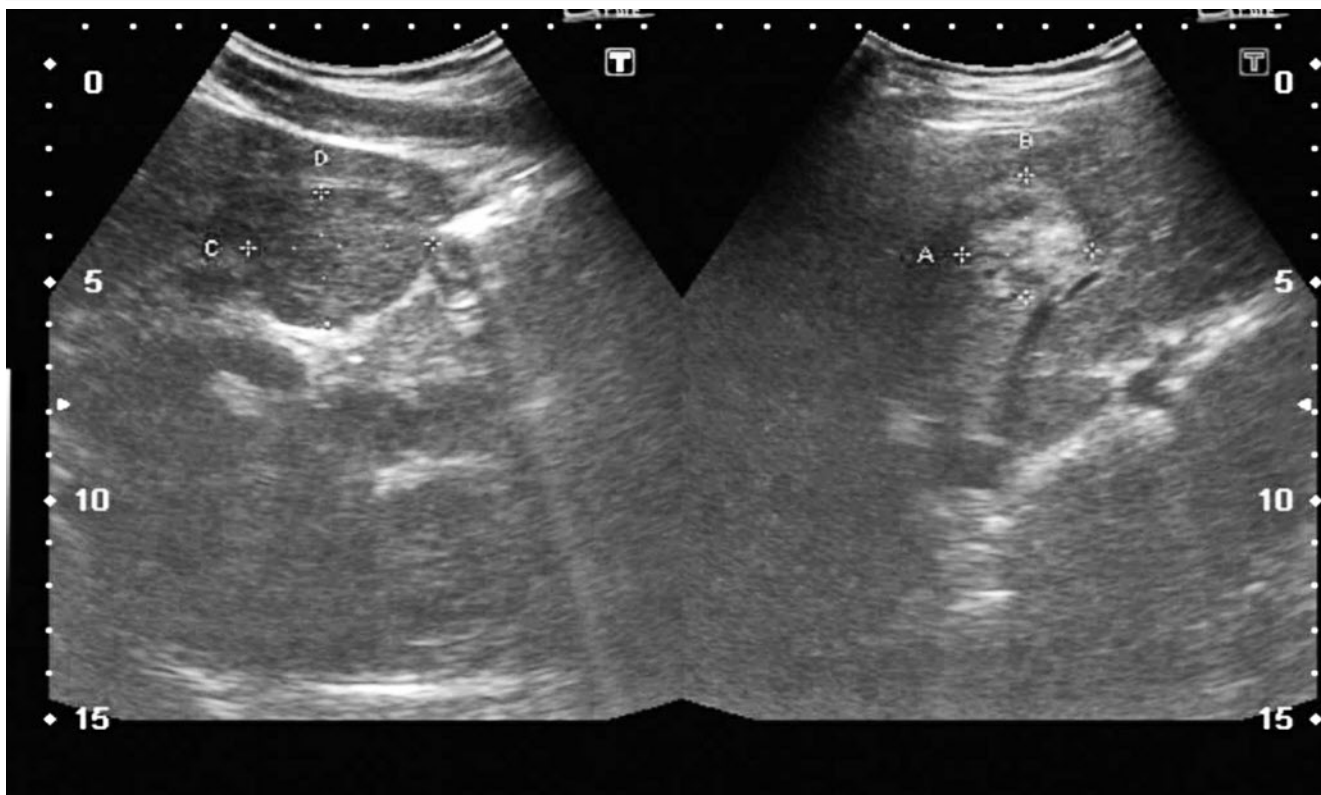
Ultrasound abdomen showing a large hypoechoic (left) and a smaller lesion with mixed echotexture (right)
